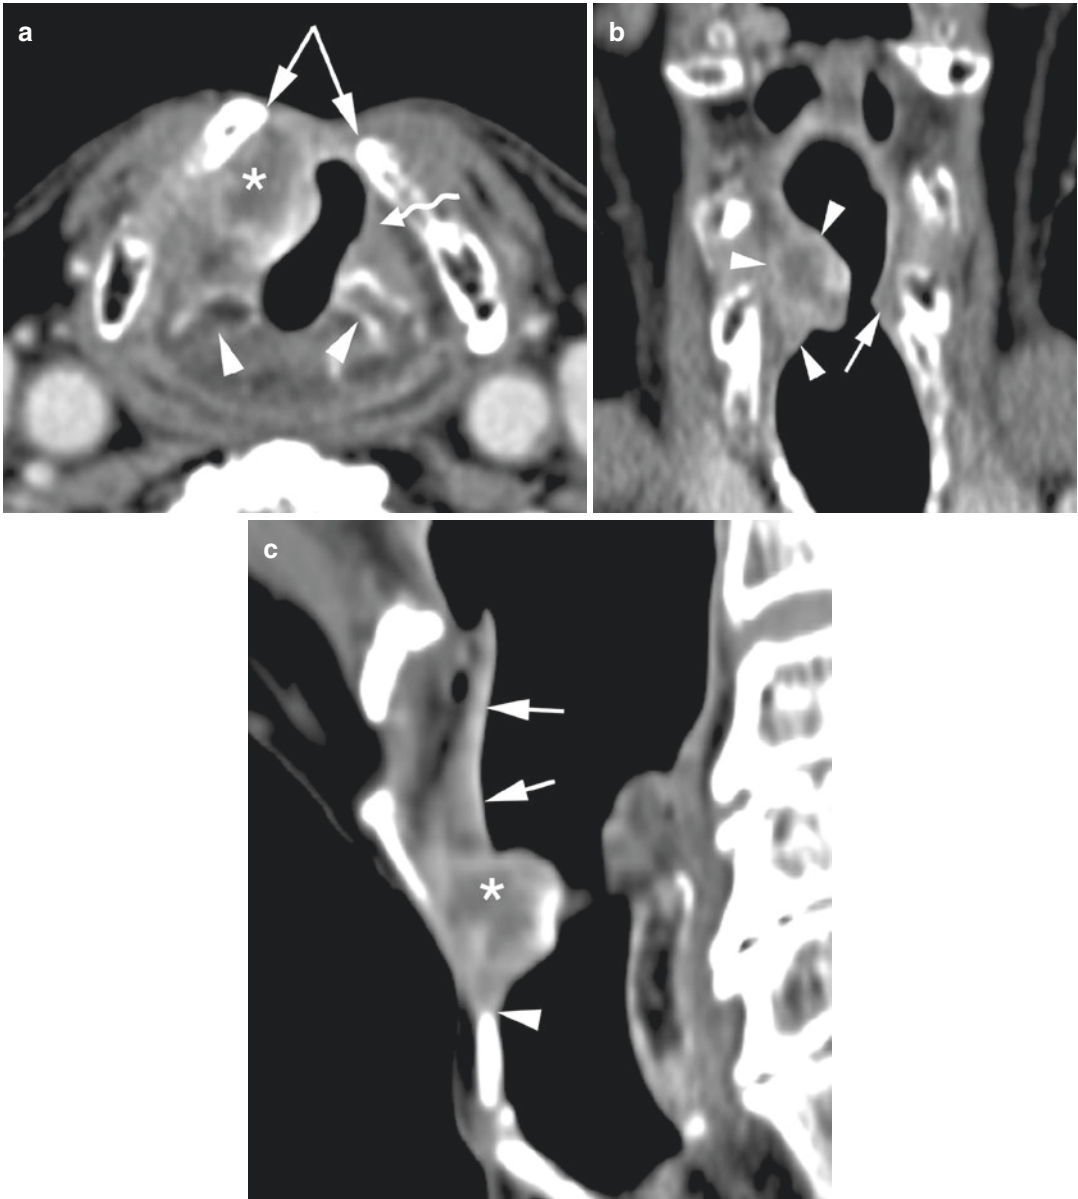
Contrast-enhanced CT images in a patient who was treated by a frontal laryngectomy (according to Tucker) for a carcinoma in the anterior commissure. Three years later, the patient presents with increasing dysphonia. Clinically, swelling of the right false vocal cord is noted with an intact mucosa. (a) Axial section at the level of the arytenoid cartilages (arrowheads). Defect in the anterior part of the thyroid cartilage (arrows); the anterior part of the left true vocal cord (curved arrow) has been resected. On the right side, a centrally necrotic soft tissue mass is seen (asterisk), indicating tumor recurrence. (b) Coronal
